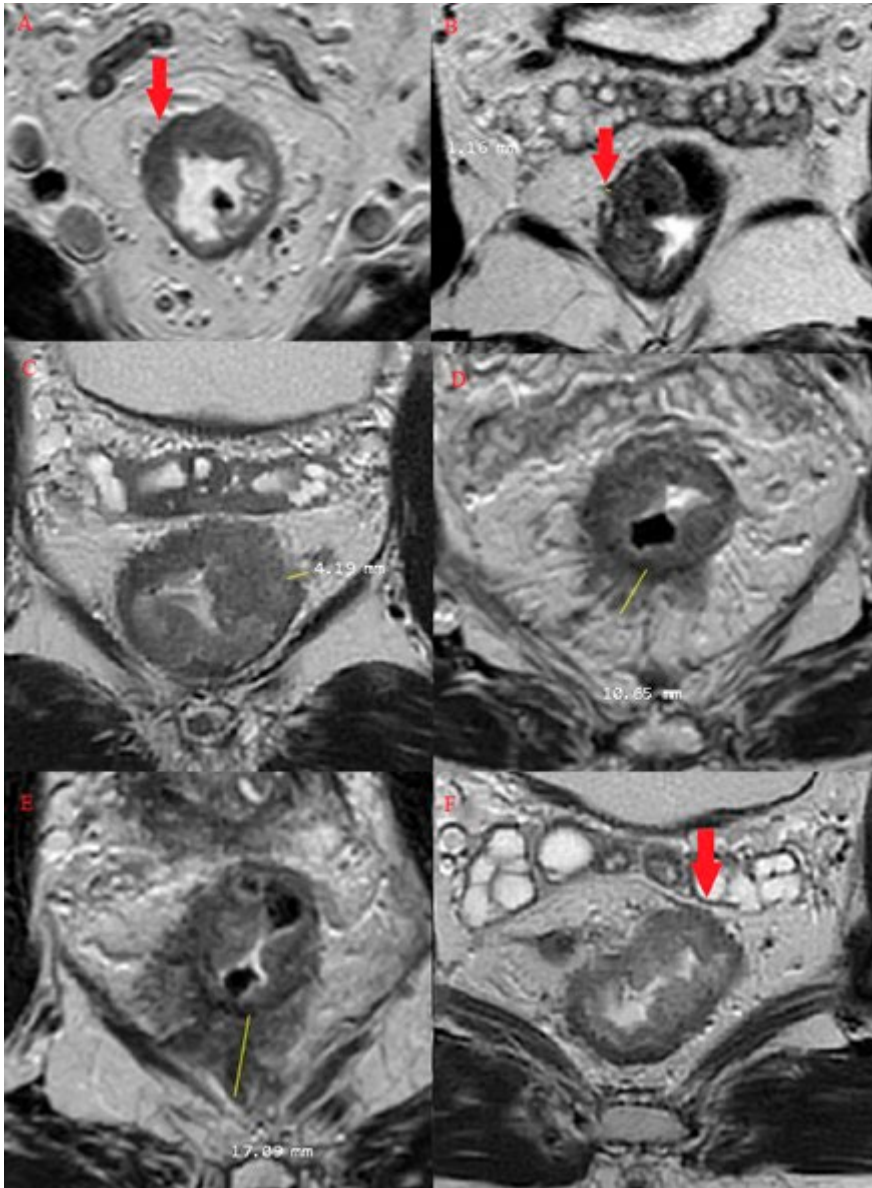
Representative MRI scans showing different invasion of the tumor into muscularis propria and beyond it
